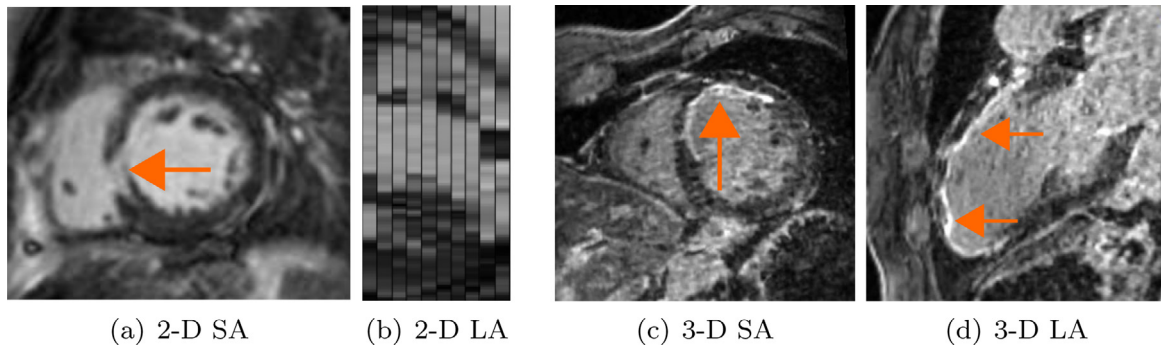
(a) 2-D late gadolinium enhanced short axis slice of the left ventricle, with a myocardial infarction (orange arrow). (b) Long axis view of the 2-D SA data, with a bad inter-slice resolution because of the large slice thickness and distance between the slices. The 2-D LGE-MRI sequence has the following parameters: pixel spacing (1.77×1.77) mm², slice thickness 8 mm, spacing between the slices 10 mm, number of slices 10. (c) 3-D LGE-MRI reorientated in a pseudo short axis view. (d) 3-D LGE-MRI in a pseudo long axis view. With the 3-D LGE-MRI an accurate quantification to the extent of myocardial scarring is possible, the orange arrows are pointing to the MI. The 3-D LGE-MRI sequence has the following parameters: pixel spacing (1.30×1.30) mm², slice thickness 1.30 mm, number of slices 120. (For interpretation of the references to color in this figure legend, the reader is referred to the web version of this article.)
